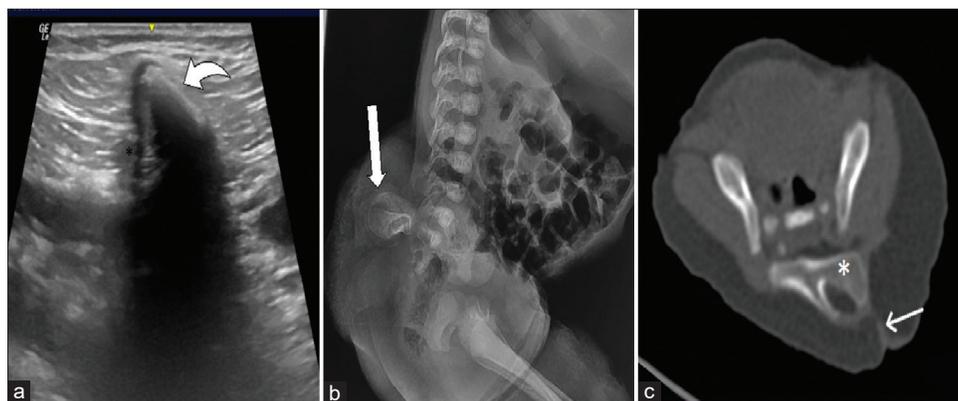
(a) An echogenic structure with dense posterior shadowing seen in the subcutaneous plane distal to the posterior midline sacral defect (curved arrow). (b) Lateral radiograph of lumbosacral spine showing a well-corticated bone in the lower sacral region posterior to the spine (thick arrow). (c) Axial CT section of the pelvis showing an extra bone posterior to the sacrum and iliac bones in the midline which is dividing into right and left limbs (*) with a hyperdense tract running anteriorly from skin surface and joining the anomalous bone (thin arrow).
